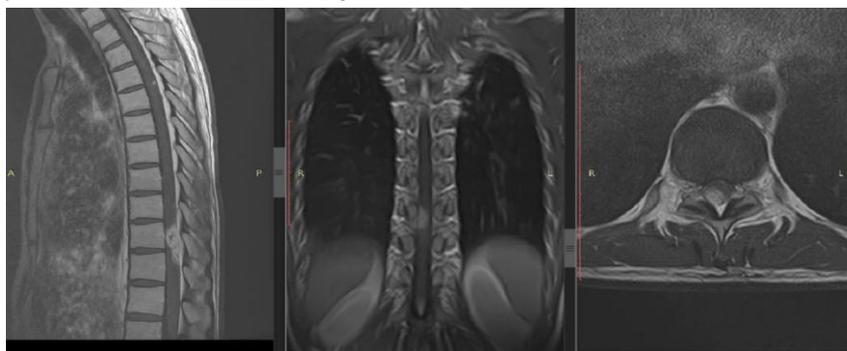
Contrast-enhanced MRI of the thoracic spine revealing an intradural extramedullary lesion at the Th10–Th11 level
